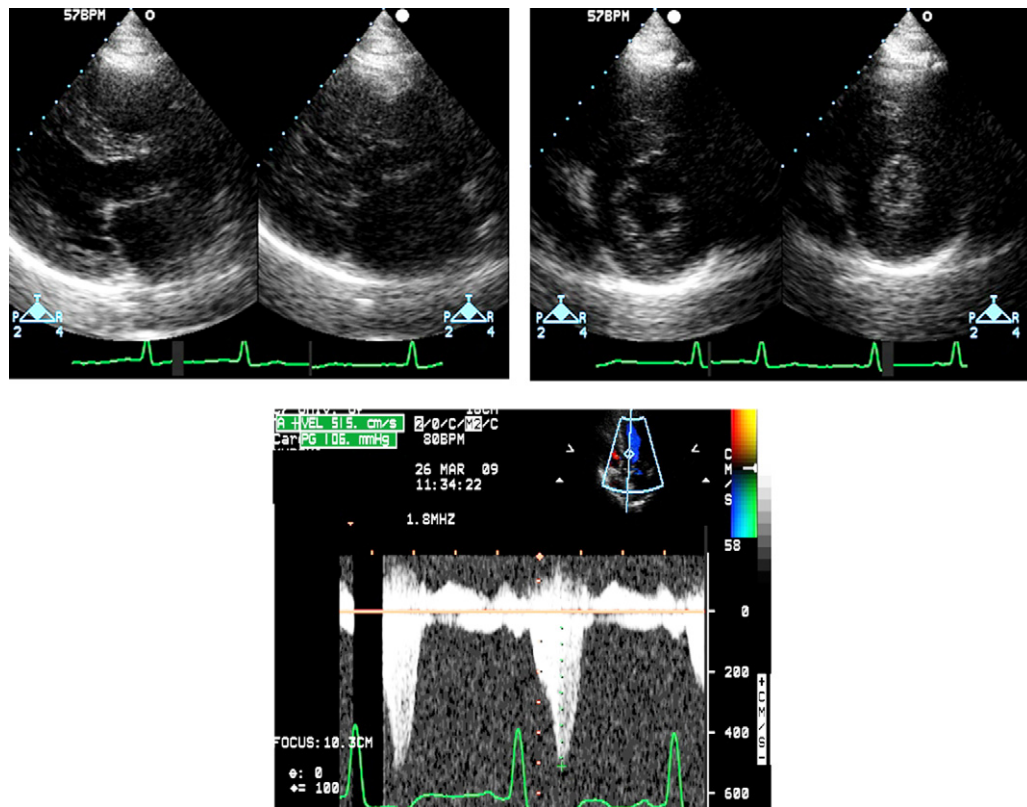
Echocardiographic findings indicating concentric left ventricular hypertrophy and preserved left ventricular ejection fraction in parasternal long-axis (top left) and short-axis (top right) views and the pressure gradient in the left ventricular outflow tract (bottom). The patient had a high pressure gradient of 105 mmHg in the left ventricular outflow tract: intraventricular septum 14 mm, left ventricular posterior wall thickness 17 mm, diastolic left ventricular diameter 43 mm, systolic left ventricular diameter 22 mm, aortic diameter 28 mm, left atrial diameter 48 mm, ejection fraction (Teichholz) 80%, left ventricular outflow obstruction pressure gradient 105 mmHg. (Color version of figure is available online.)
